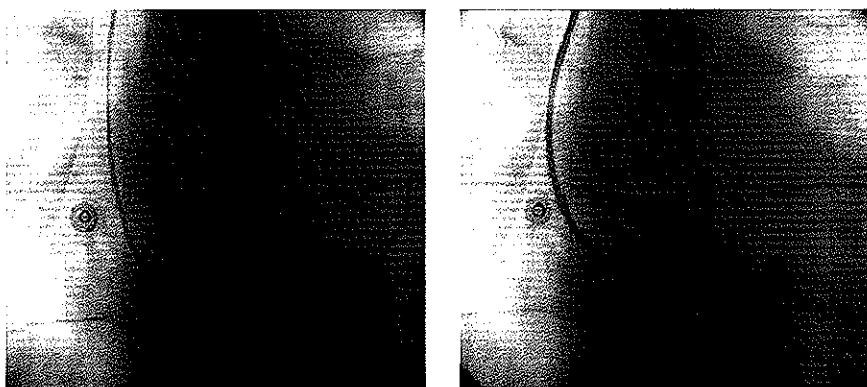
AP fluoroscopy view of the intra-cardiac echocardiography transducer introduced into the heart. Left panel: femoral approach; right panel: subclavian approach.
